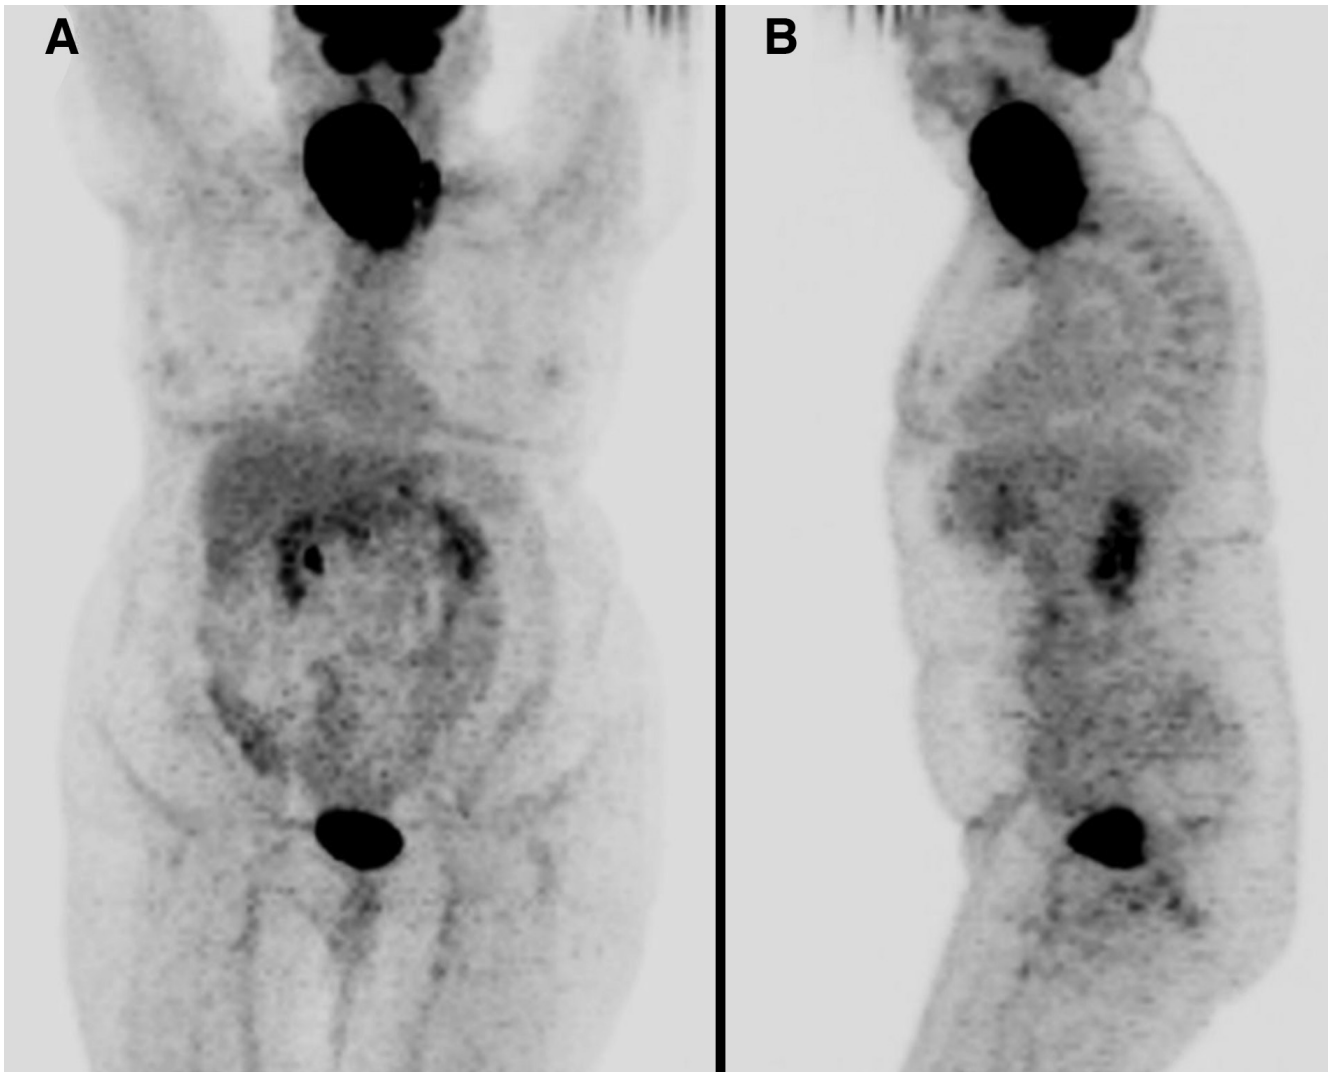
A 67-year-old woman with no prior history of benign thyroid disease presented with a two month history of fevers, night sweats, and rapidly enlarging neck mass. Biopsy of the right thyroid lobe revealed a diffuse large B-cell lymphoma (DLBCL). A staging ^{18}F -fluoro-2-deoxy-D-glucose (^{18}F -FDG) positron emission tomography/computed tomography (PET/CT) (Discovery-ST, GE Healthcare, WI, USA) was performed and maximum intensity projection (MIP) images, (A) anterior and (B) left lateral, showed a large intensely ^{18}F -FDG avid mass in the right neck with no distant metastases.
